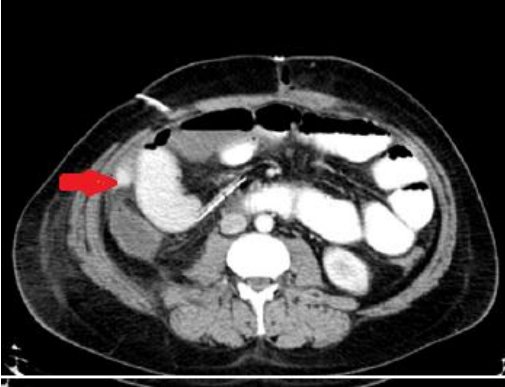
Oral and IV contrast axial CT, of a male patient postoperative follow up, revealed: mild amount of free pelvi-abdominal fluid extending from right iliac fossa lateral to ascending colon with dense fluid collection.....denoting contrast leakage.
